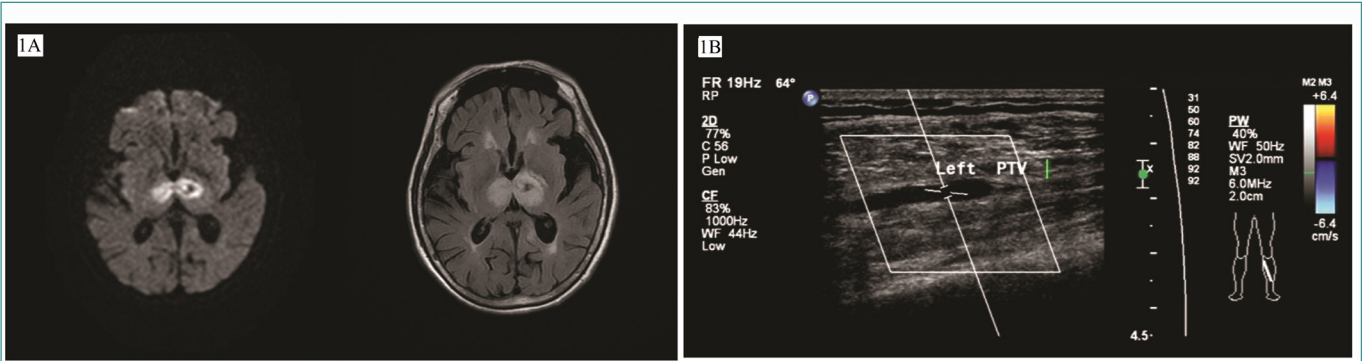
A) Axial diffusion-weighted MR image of brain & Axial T2-weighted MR FLAIR image showing bilateral hyperintensity in the thalami indicating of infarction. B) Intraluminal echogenicity in the left posterior tibial vein showing DVT.
